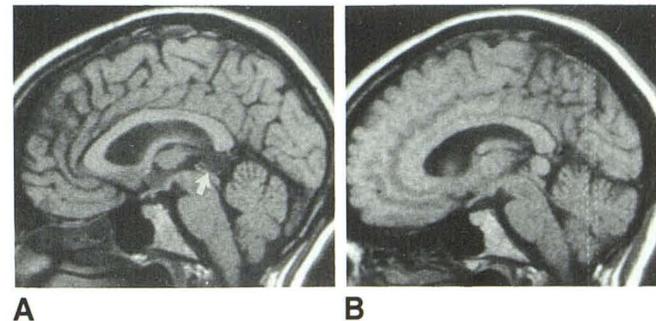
A, Unenhanced MR image shows a sharply margined pineal cyst (arrow) with low signal intensity. B, On delayed image obtained after administration of contrast material, cyst enhances but appears isointense with corpus callosum.
